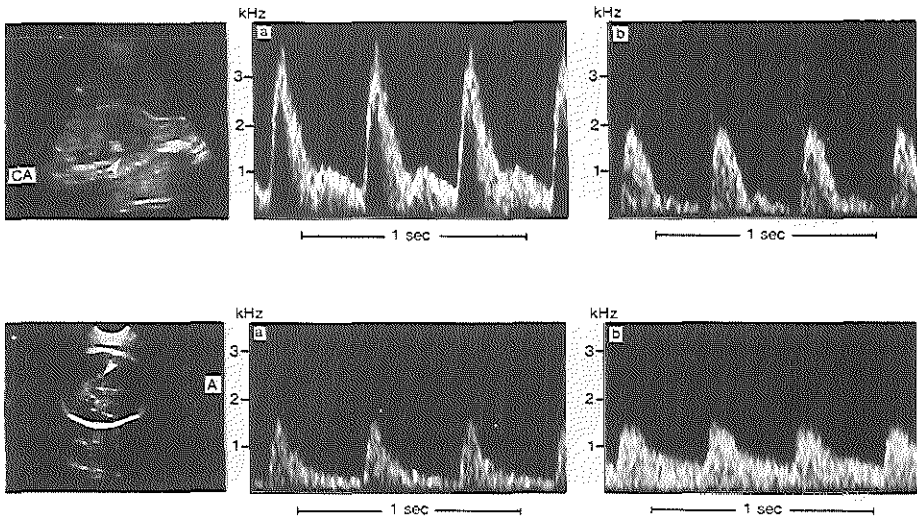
Top panel: Two-dimensional sagittal cross section through the fetal trunk with Doppler flow velocity waveform tracings from the fetal descending aorta (see arrow) during normal pregnancy (a) and intrauterine growth retardation (IUGR) (b). CR, cranial; CA, caudal. Bottom panel: Two-dimensional transverse cross section through the lower part of the fetal brain at the level of the heart-shaped cerebral peduncles (see arrow) with Doppler flow velocity waveform tracings from the internal carotid artery during normal pregnancy (a) and IUGR (b). A, anterior; P, posterior.
